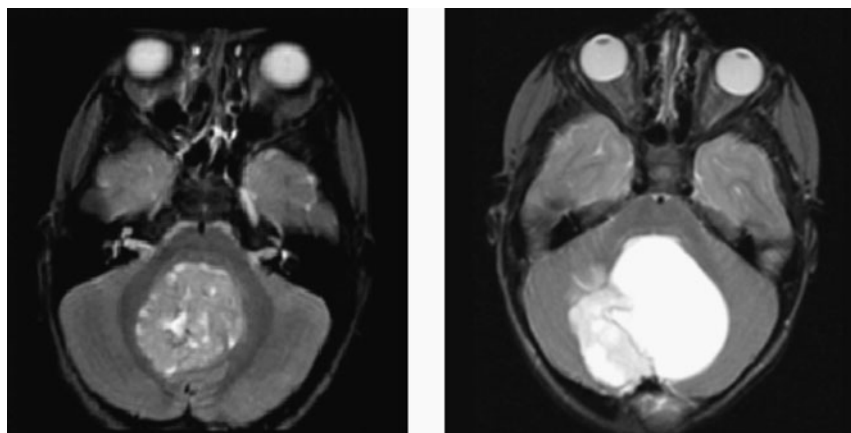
Magnetic resonance imaging axial images taken prior to surgical resection of large masses of cerebellar medulloblastoma (MB; left) and astrocytomas (AST; right). Both cases show tumors with a midline cerebellar vermis location.
